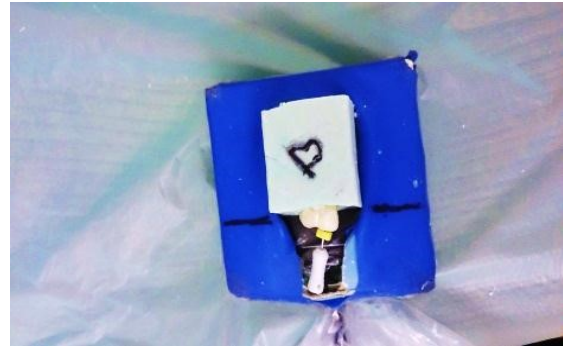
Placement of a sample in the mounting jig prior to digital radiography
